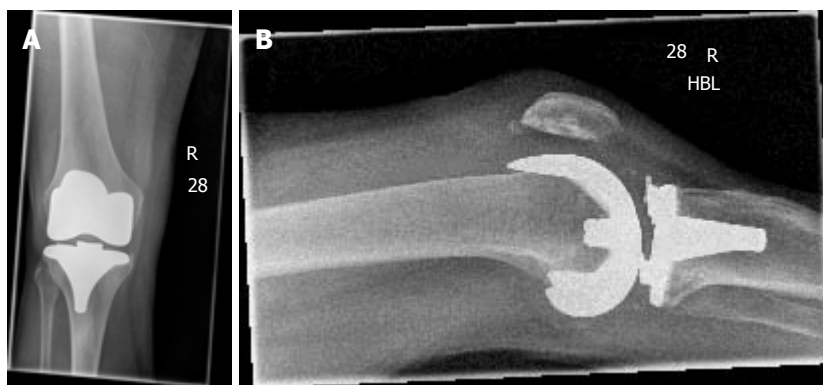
Initial radiographs of the right knee. A: Anterior-posterior radiograph of the right knee; B: Lateral radiograph of the right knee.
